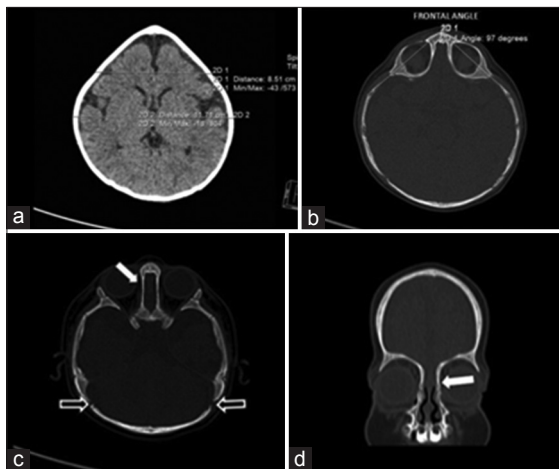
Multidetector computed tomography showing (a) increased ratio of interparietal and intercoronal distance (b) showing decreased frontal angle (c and d) decreased interorbital distance
